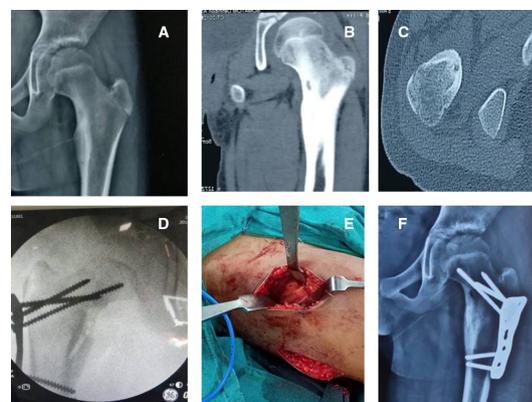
Radiograph of the right hip showing sclerosis anteromedial aspect of femoral neck with nidus surrounded by radiolucent rim in (A); CT scan images demonstrating eccentric lytic lesion with reactive bone sclerosis (B, C); intraoperative and intensifier images showing the PHILOS plate and excised calcar (D); surgical image showing double incision (E) and follow-up radiograph showing bone healing and implant in-situ in (F). PHILOS, proximal humerus internal locking system.
